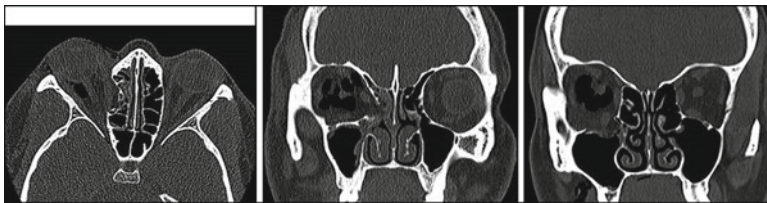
Orbita CT revealing impression of the lamina papyracea, impression of the orbita floor, and an intra-orbital hematoma. *Left:* axial section. *Middle and right:*
